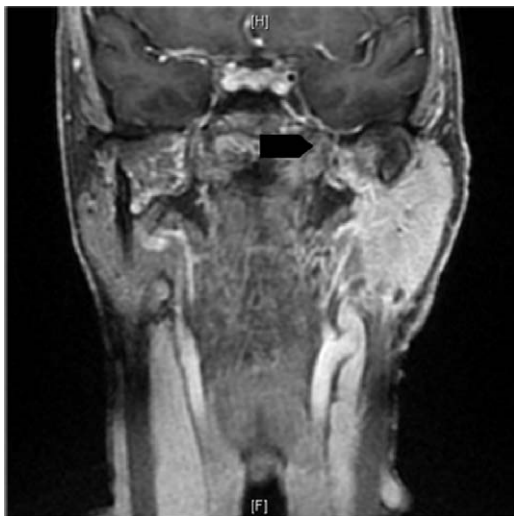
MRI (frontal plane) with gadolinium injection showing homogenous enhancement of the entire left parotid gland, bypassing the mandibular condyle and extending medially to the foramen ovale (black arrow) and laterally to the tympanic bone (not shown). The left parotid gland measures 36.3 mm in transverse diameter and 47.6 mm in anteroposterior diameter versus 28.3 mm and 45.1 mm for the right gland, respectively.
